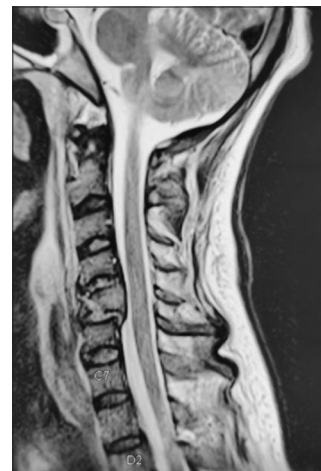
Magnetic resonance imaging T2 sagittal view demonstrating the fracture with posterior shift of proximal spinal column
